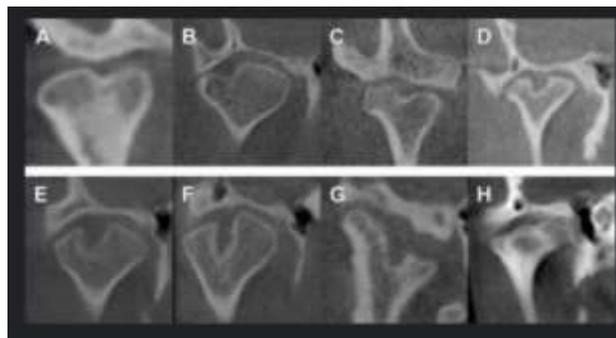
Computed Tomography
